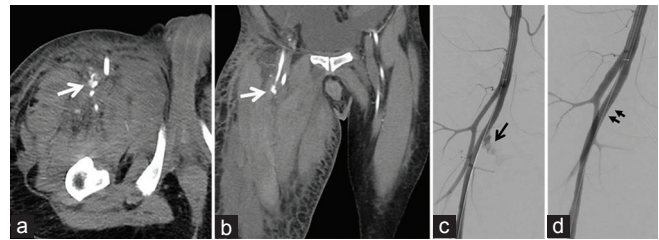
(a) Axial and (b) coronal computed tomography angiogram showing active extravasation from the right superficial femoral artery (white arrows) with no catheter in place. (c) Angiography showing the bleed from the proximal superficial femoral artery (black arrow). (d) Arterial injury was treated stent-graft placement (black arrows)
